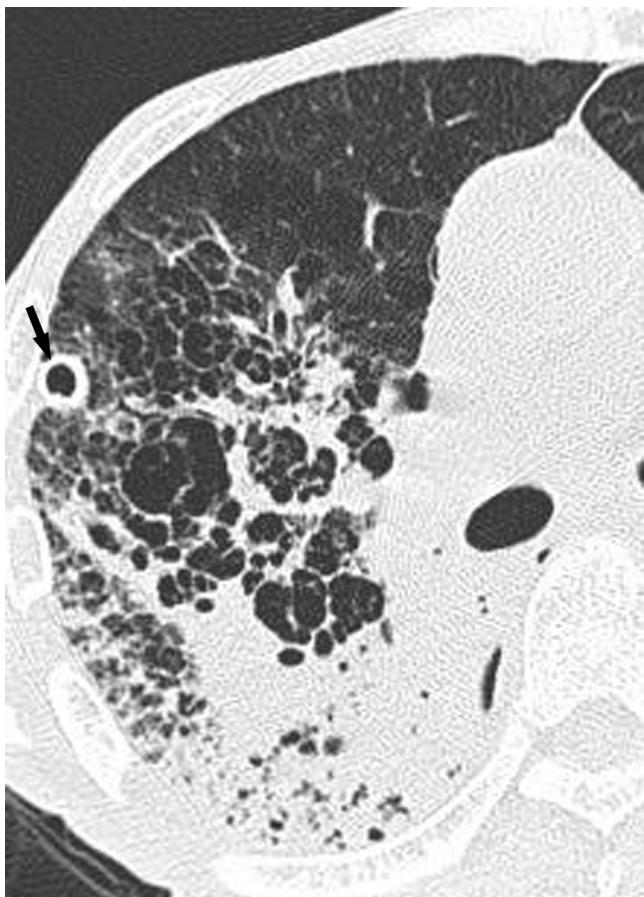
“Swiss cheese” appearance in pneumonia superimposed on emphysema in a 67-year-old man. High-resolution computed tomography shows a large area of heterogeneous air space opacity with innumerable small air cysts, emphysema cysts, resulting in Swiss cheese appearance. This appearance may be confused with one of ground glass opacity with bubbly lucency in bronchioloalveolar carcinoma. A drainage tube is kept in the right pleural cavity (arrow).
